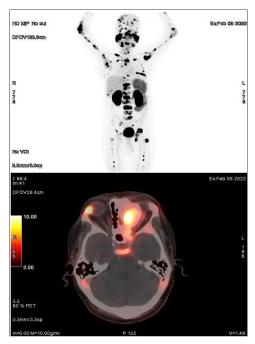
PSMA-PET Showing Sphenoidal Bone Metastasis and Metastatic Disease Burden Elsewhere.
